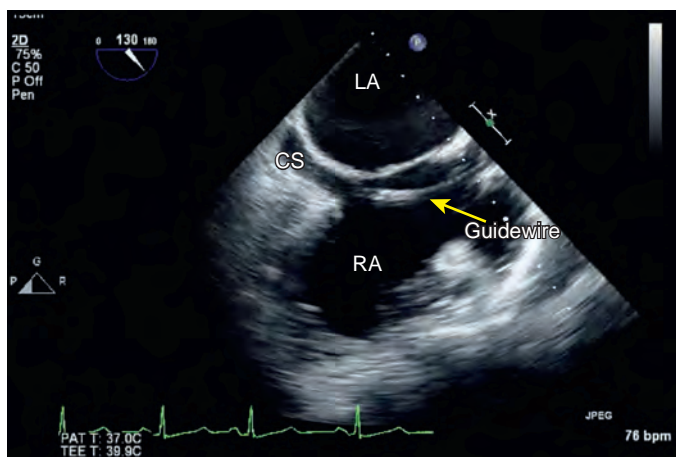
Echocardiographic guidance for cannulation of the coronary sinus (CS). The guidewire is shown advancing toward the CS on a midesophageal modified bicaval view. LA, Left atrium; RA, right atrium.
